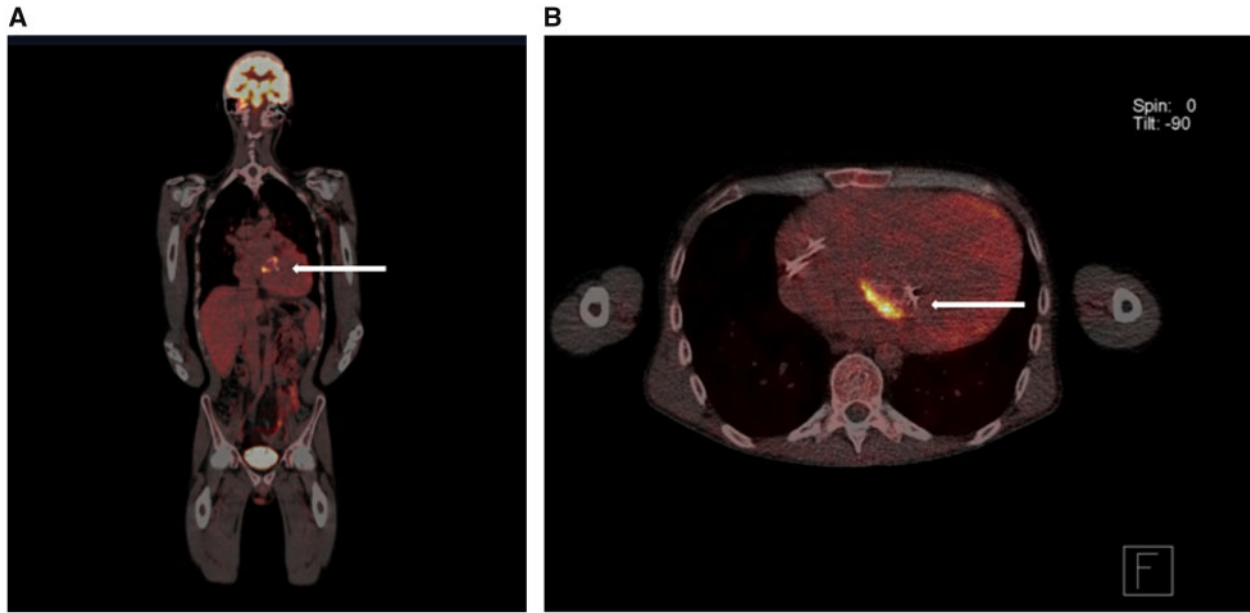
Longitudinal (A) en transversal (B) positron emission tomography-computed tomography (PET-CT) images, demonstrating uptake of the fluorodeoxyglucose (FDG) at the tricuspid valve (systemic atrioventricular valve) indicating inflammation (arrows). No other parts of the body are affected, proving the isolated infection of the heart only.
